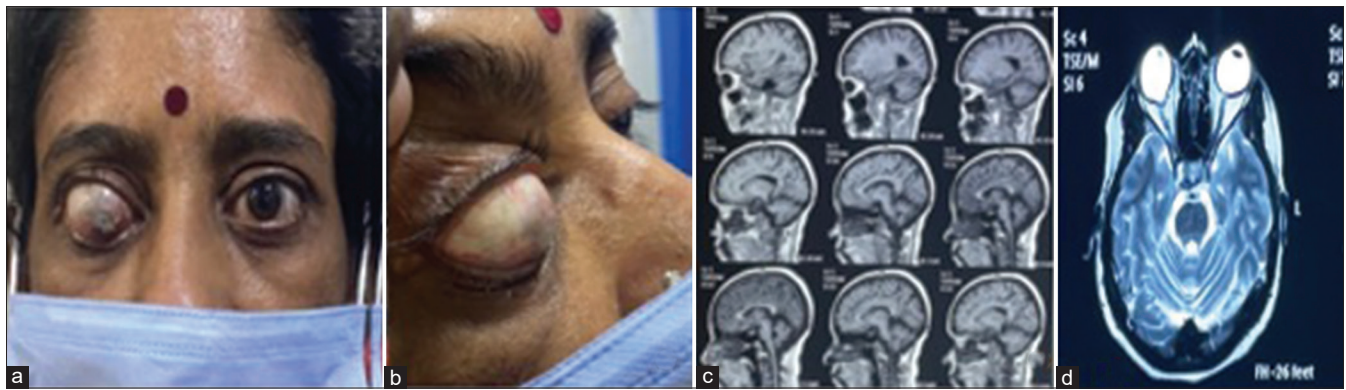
(a) External photograph of the patient with right pseudoproptosis. (b) Enlarged side view showing the prominence. (c) MRI brain showing atrophic cerebellum characteristic of spinocerebellar ataxia. (d) MRI orbit-axial scans of orbit at the time of diagnosis of spinocerebellar ataxia (no pseudoproptosis earlier)
